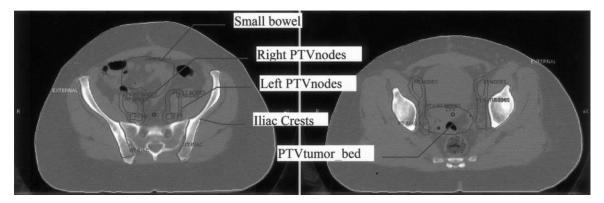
Two computed tomography slices contoured with planning target volumes (PTV),  $PTV_{tumor\_bed}$ , and  $PTV_{nodes}$ , small bowel, and iliac crests.
